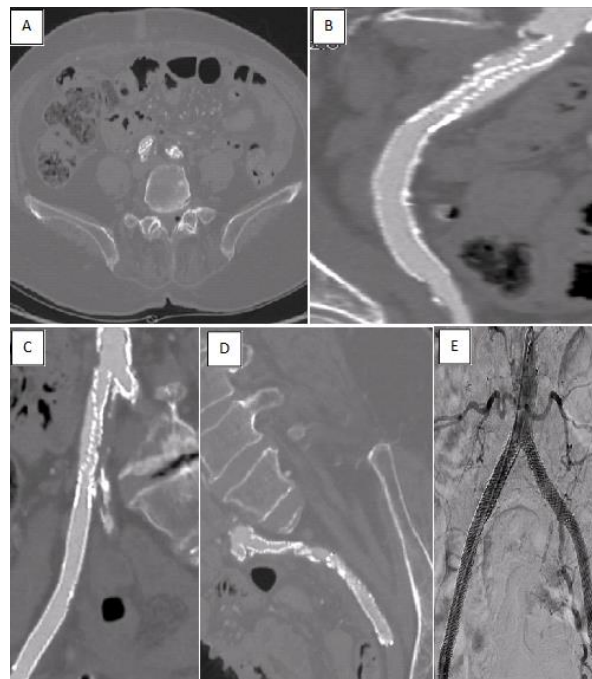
(A and B): Post-operational control CTA showed evidence of bilateral balloon-expandable stents compression, (C and D): which was more prominent on the right side. (E): DSA of bilateral iliac arteries following implantation of self-expanding stents.
